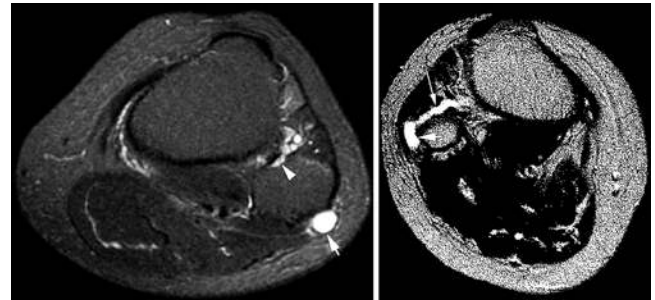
Previously reported cases with new joint connection. Left: Axial T2-weighted fat-saturated MR image of the leg at the level of the mid-fibular head demonstrates cyst in the common peroneal nerve (arrow). A previously unrecognized classic “tail sign” is seen on this image (arrowhead). Modified from Hahn SB, Choi CJ, Kang HJ: [Intraneural ganglion of the peroneal nerve—a report of 3 cases.] *J Korean Orthop Assoc* 41:163–166, 2006 (Korean). Published with permission. Right: Axial non-fat-saturated T2-weighted MR image demonstrating a “transverse limb” sign¹⁴⁶ (thin arrow) in this example of a peroneal intraneural ganglion (arrow). The finding of cyst within the articular branch is classic and diagnostic of the joint-related nature of the intraneural ganglion despite the low-quality reproduction of the original image in its published form. Modified from Park GY, Bae JH, Lee SY, Lee SM, Kong KS: [Common peroneal nerve palsy caused by an intraneural ganglion—a case report.] *J Korean Acad Rehab Med* 30:289–293, 2006 (Korean). Published with permission.
